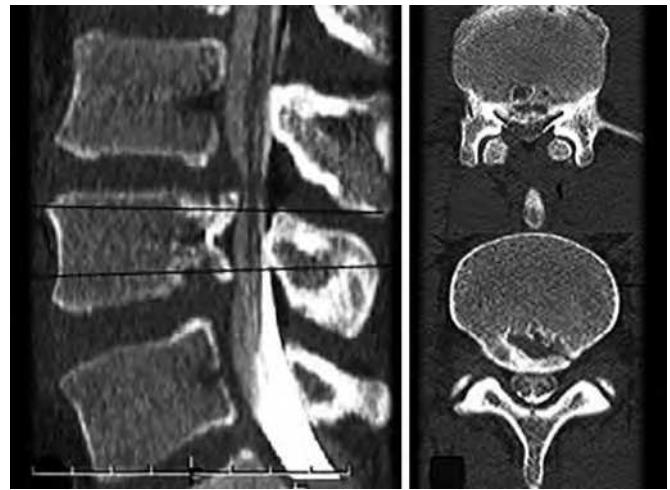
Reconstructed computed tomography scans showing the osseous fragments of the cross-sectional area at both the inferior and the superior L4 rim.
